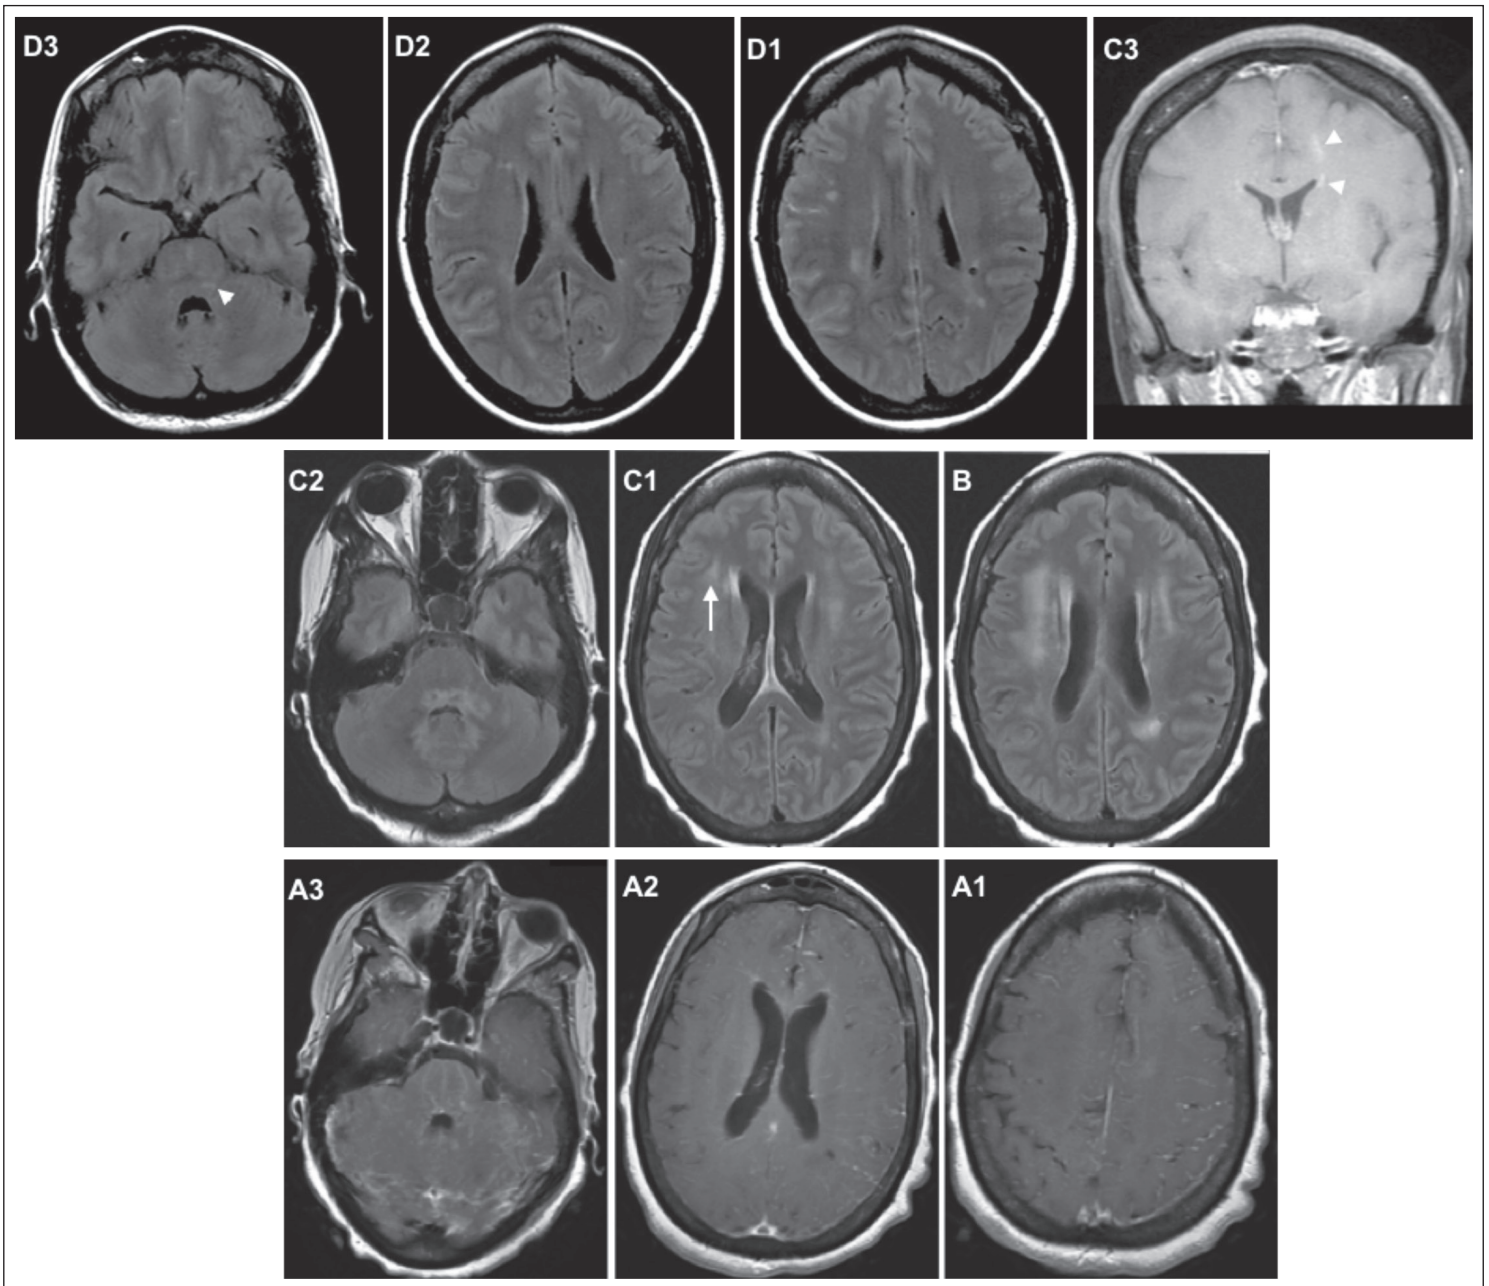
(A1-3) Baseline MRI, T2-fluid-attenuated, inversion recovery (FLAIR) image, for SD showing multiple hyperintense areas involving the brainstem (white arrowhead), adjacent to the lateral ventricles and deep white matter (B) two of which enhanced after administration of gadopentetate (white arrowheads). (C1-3) MRI, T2-FLAIR image, performed 3 years later for JP showing increased T2 load suggesting chronicity. Note that the majority of T2 hyperintensities are located in the deep white matter and are not discrete lesions. Additionally, a lesion near the cortex (white arrow) fails to involve the cortico-cortical connecting fibers as commonly seen in MS. (D1-3) Gadolinium-enhanced T1 image, showing waspy pattern on enhancement involving the pons as well as leptomeningeal involvement.
